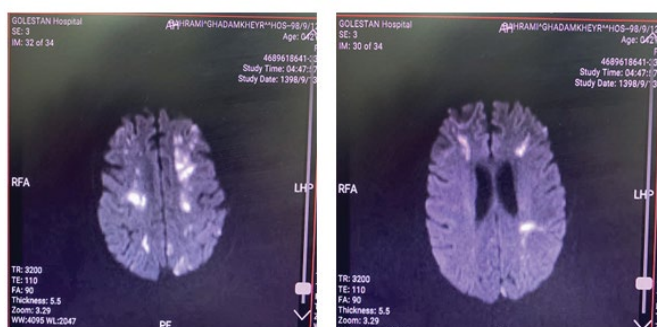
MRI with multiple small and ill-defined white matter demyelinating foci in the supratentorial level.
